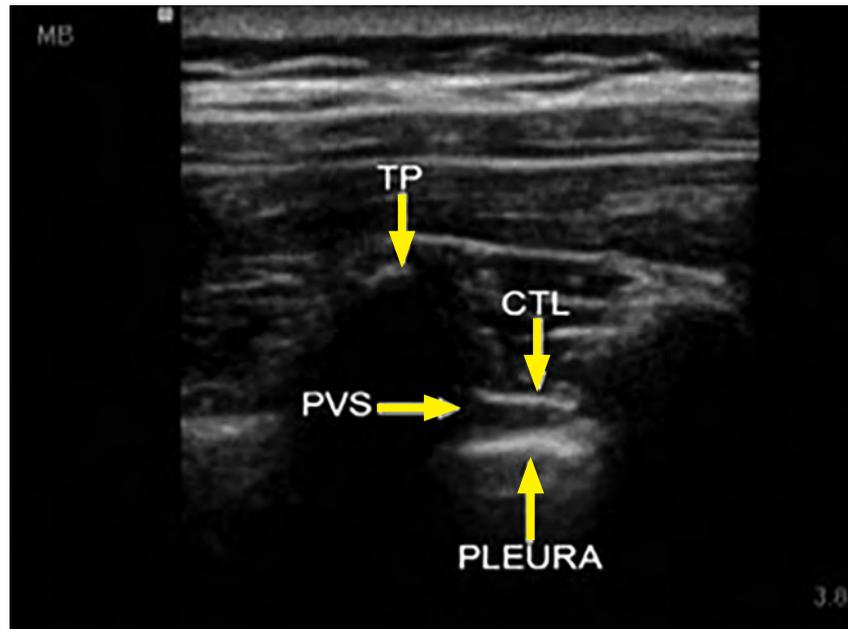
Ultrasound-guided TPV nerve block using a paramedian sagittal scan.
